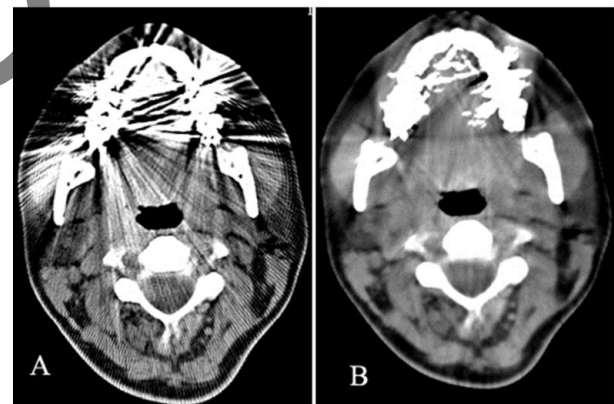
An example of neck CT images before (A) and after (B) performing the filter of “body standard metal kernel”
